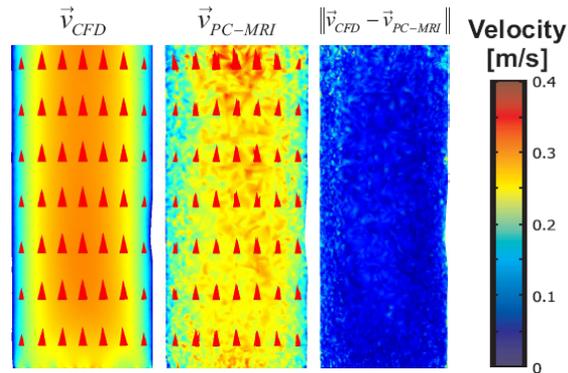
Flow velocities in the tube model calculated using CFD and measured using PC-MRI.
